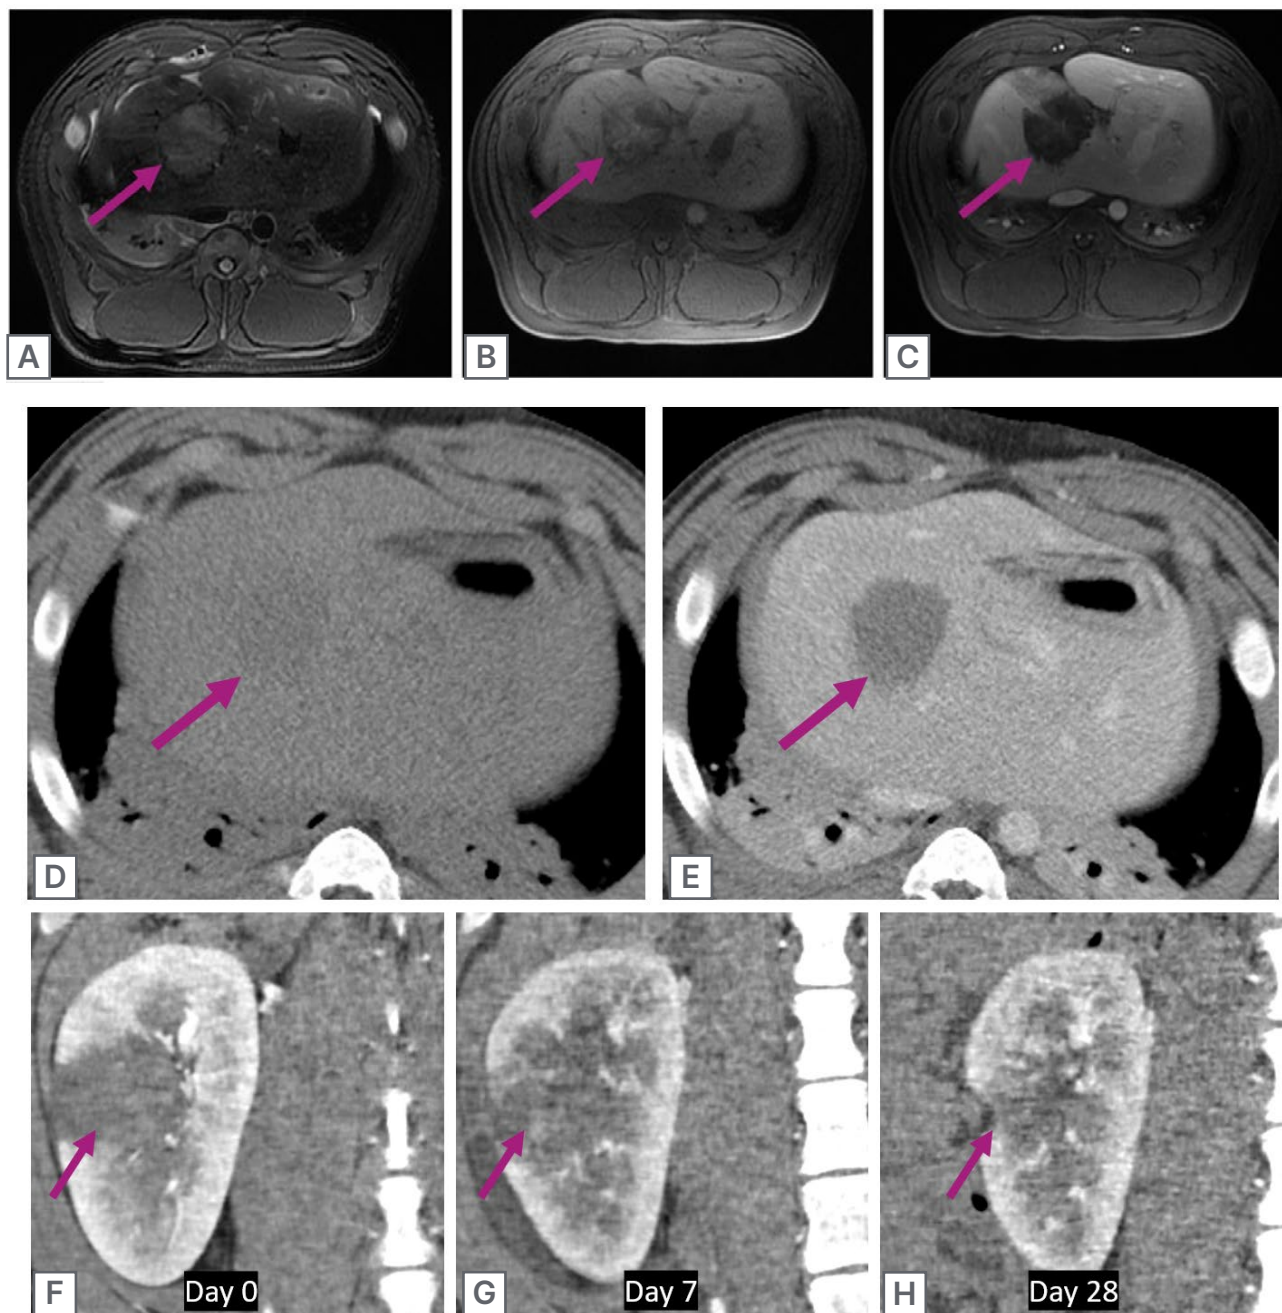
Cone beam CT-guided histotripsy.
